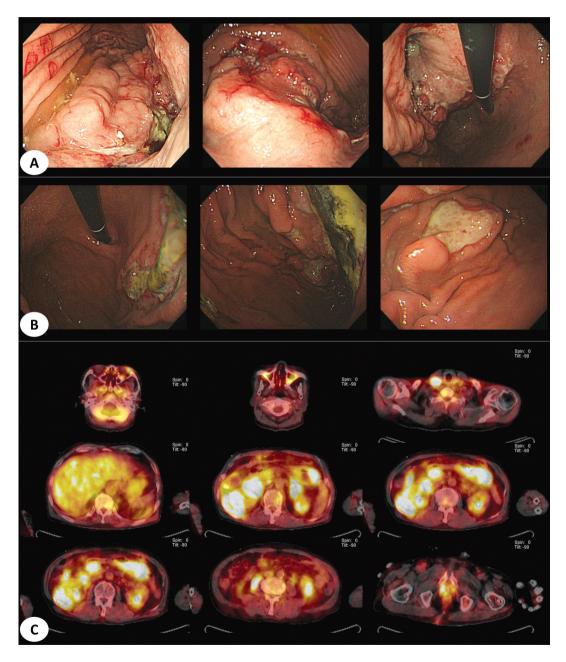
Endoscopically ulceroinfiltrative lesions of two cases. (A) Primary gastric lymphoma which was diagnosed as mantle-cell lymphoma. (B) Secondary gastric lymphoma which was diagnosed as DLBLC. (C) Multiple involved lymph nodes and organs were observed on PET-CT in same patients of B (Abbreviation. DLBCL, diffuse large B-cell lymphoma; PET-CT, positron emission tomography-computed tomography).
